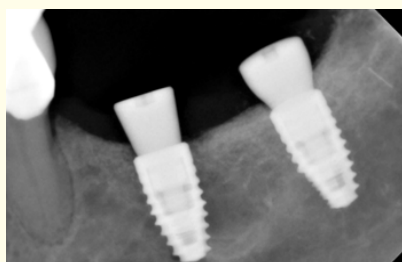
Post-immediate x-ray.
